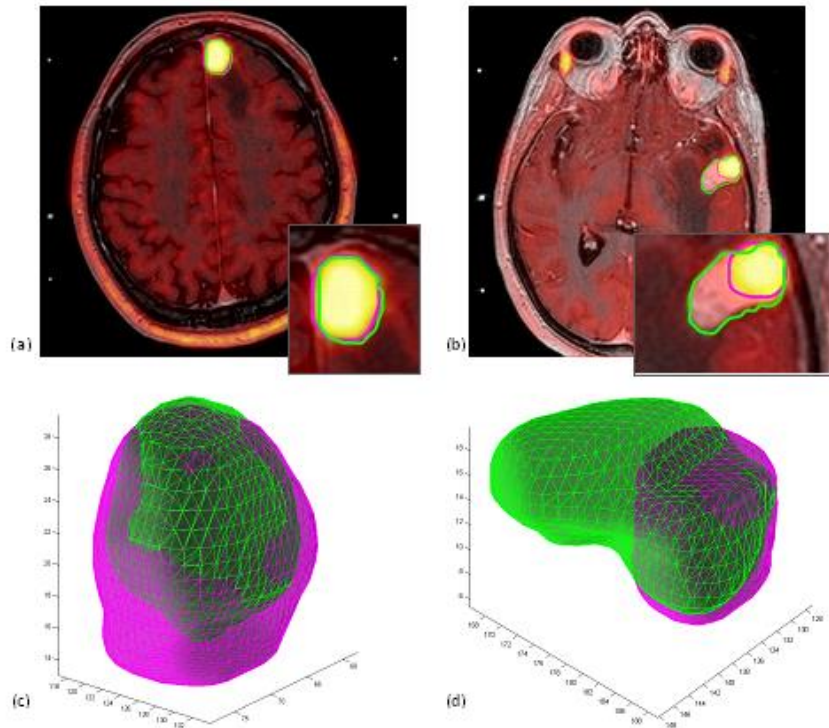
Results achieved by the proposed multimodal PET/MRI segmentation method on the input image pairs reported in Figure 25. The BTV_{MRI} (magenta contour) and GTV (green contour) are superimposed: (a) boundaries computed on PET and MR images are nearly overlaid; (b) the two ROIs are very different in this case. At the bottom right, a blow-up of the lesion regions is shown in both cases. 3D volume reconstruction of brain tumors in (a) and (b) are shown the lesions in (c) and (d), respectively.
